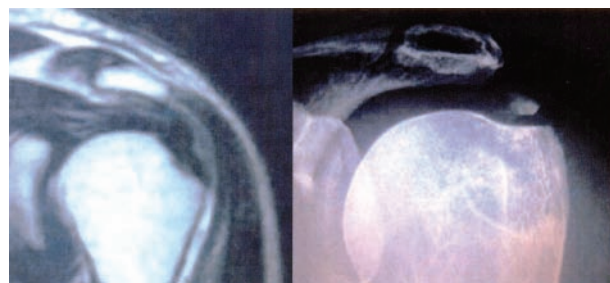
Calcium deposits in the supraspinatus tendon (MRI and plain radiograph).
